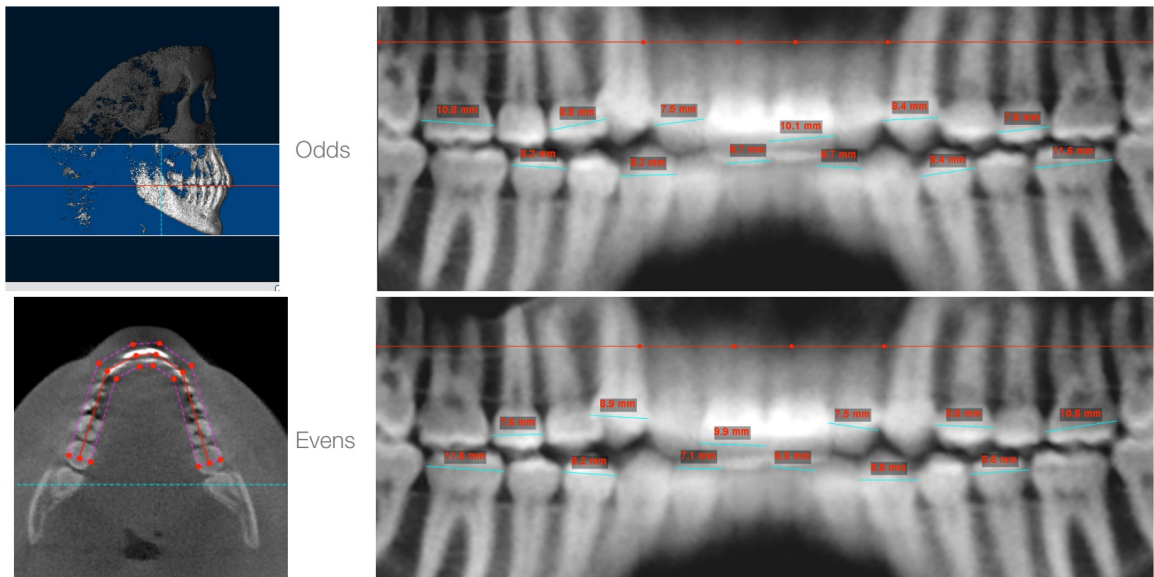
Method 5: CBCT Simple Pano - Dolphin.
